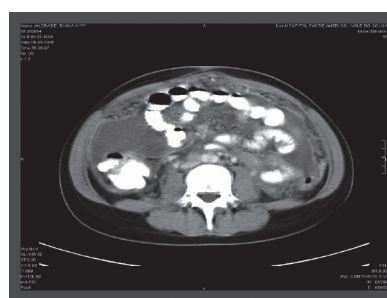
CT transverse scan: dense, granular ascitis with enhanced peritoneal captation of contrast and swelling of the bowel wall.
